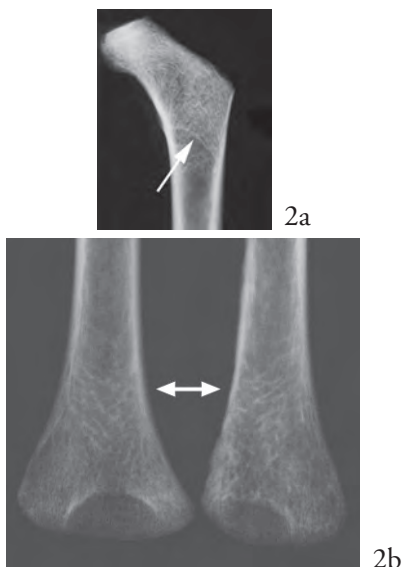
Harris lines on an X-Ray image of the proximal femur (a) and the distal humerus (b).
